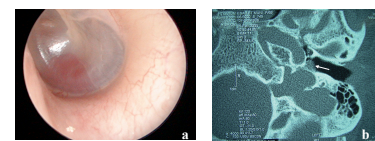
Otolaryngology shows red mass behind the tympanic membrane. Figure 5b: Axial HRCT temporal bone shows protruding mass in middle ear cavity. (arrow)
